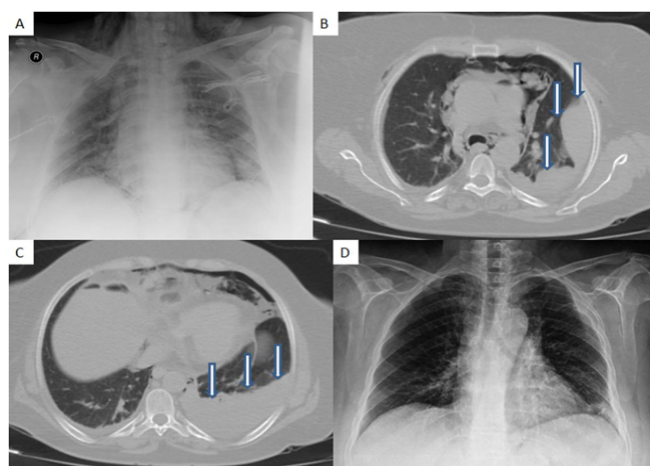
Chest X-ray after tube thoracostomy (a), CT image of hemothorax and subpleural hematoma secondary to tube thoracostomy (b,c), control chest X-ray taken 2 weeks after discharge of the patient (d).
